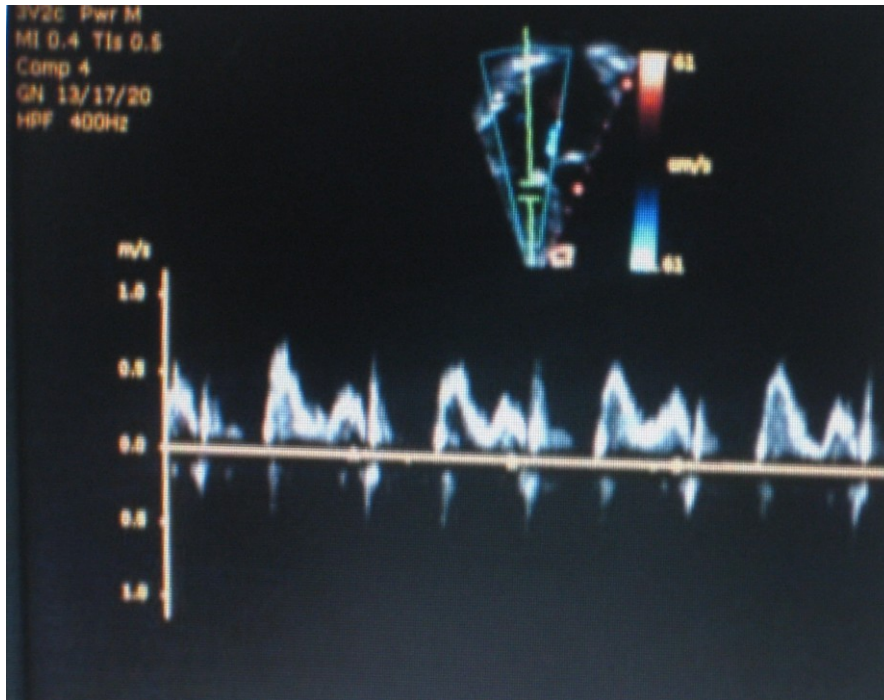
Pulsed wave Doppler applications in the apical four-chamber view at the level of tricuspid valve leaflets. The duration of ICT+ IRT is measured from the cessation of tricuspid valve inflow to the onset of the tricuspid valve inflow (from the end of the A wave to the beginning of the E wave). This represents the (a) variable in the equation.
